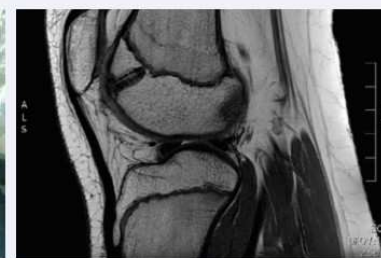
Postoperative MRI image obtained at the 1 year follow up visit showing healing of the chondral fracture.
